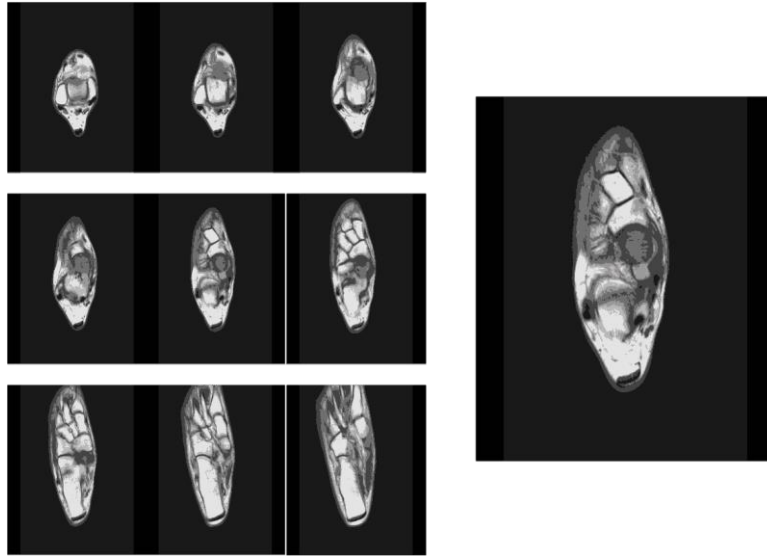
Right Ankle MRI T1W Axial View.
